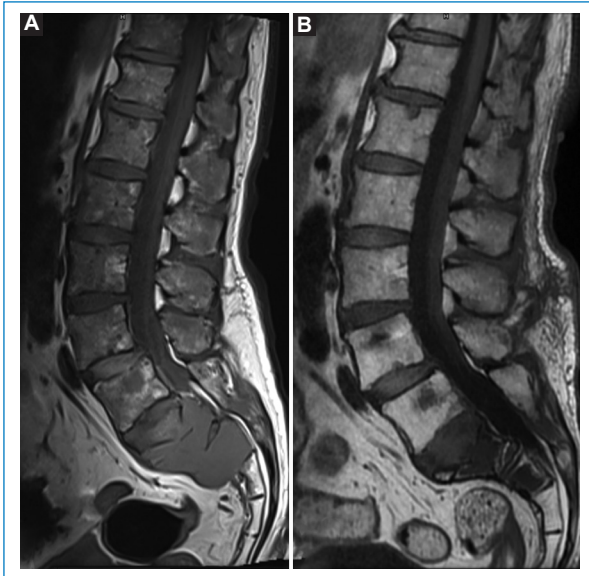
Pretreatment T1 sagittal MRI of the lumbar spine (A) showing expansive lesions in S1 and S2, isointense to the muscle, with fracture in the pathological bone of S1, in addition to a “salt and pepper” infiltrative pattern in the remaining vertebral bodies, and sagittal MRI of the lumbar spine T1 after treatment (B) with normalization of the T1 signal of the lumbar bone marrow, decreased signal of the sacral lesions and appearance of high T1 signal edges, compatible with complete or partial response.
